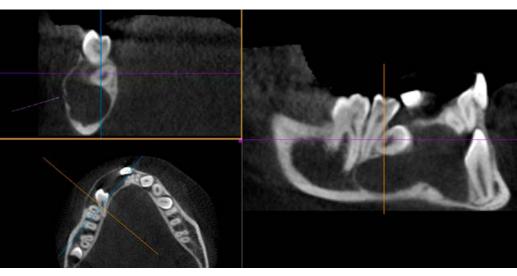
CBCT showing the extent of the lesion as well as it's intimate association with the CEJ of the lower right 1st premolar in a coronal view (top left) with the purple arrow indicating the ocation of the mental foramen, sagittal view (right) and axial view (bottom left).
